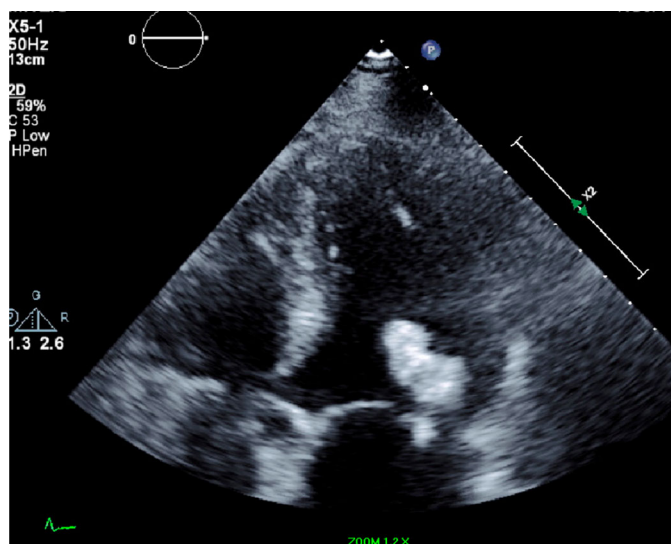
Transthoracic echocardiogram, four-chamber view, showing mitral annular calcification and a long, mobile, serpiginous mass (2.7×0.9 cm) below the mitral valve posterior leaflet, attached to the mitral valve chordae.
